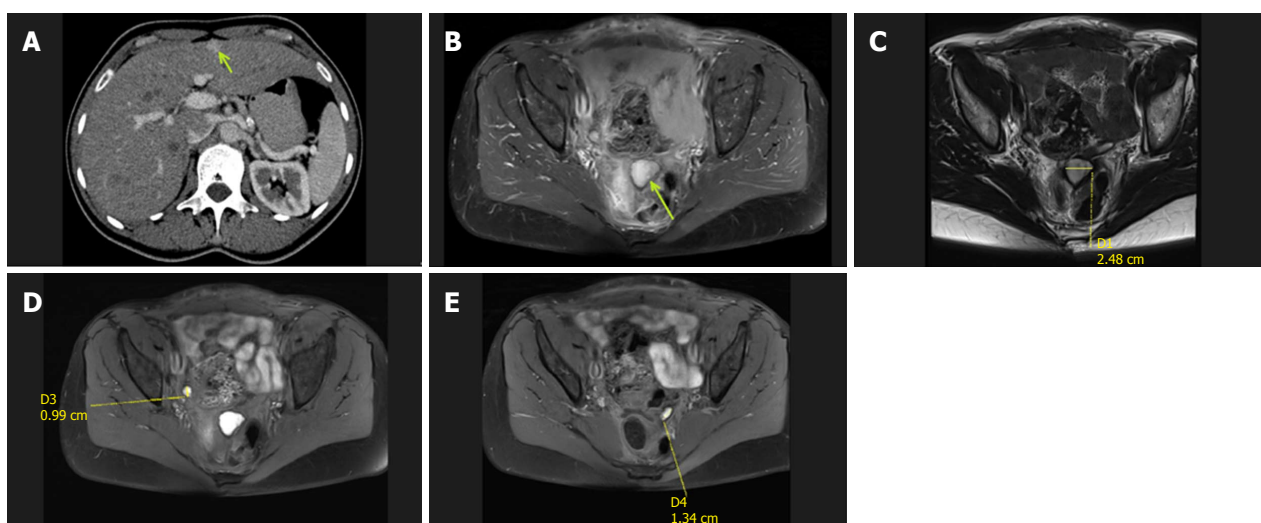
Abdominal computed tomography and abdominopelvic magnetic resonance scans. A: Post-contrast computed tomography image in the portal venous phase showing a hyperintense enhancing lesion in segment V (isodense in the native phase) of the liver, which was diagnosed as a superficially located suspicious metastatic lesion; B-E: Abdominopelvic magnetic resonance scans with evident masses and suspicious nodules.
